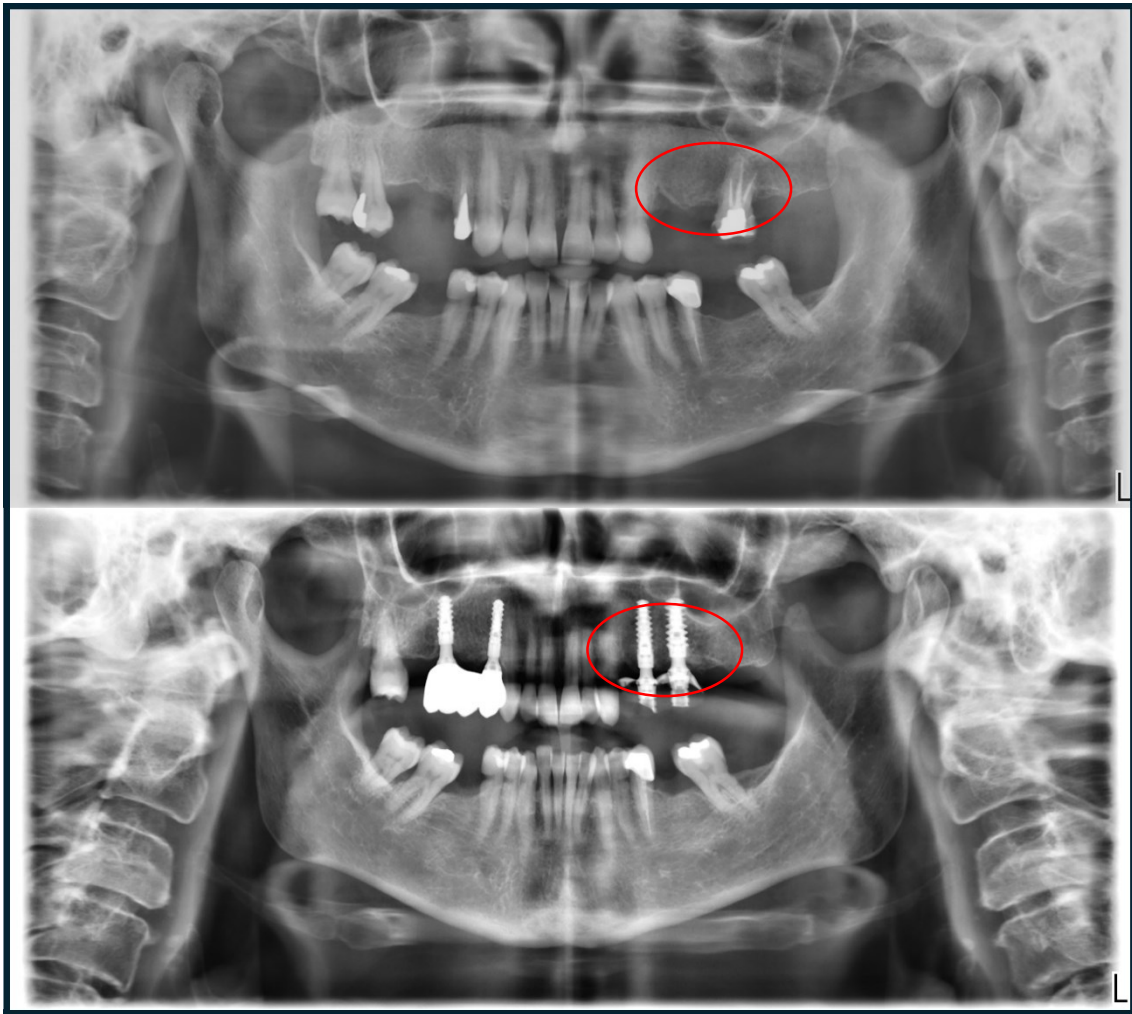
Patient SP3, orthopantomography comparison time 1 11/12/2020 (above), time 2 03/07/2024 (below)
